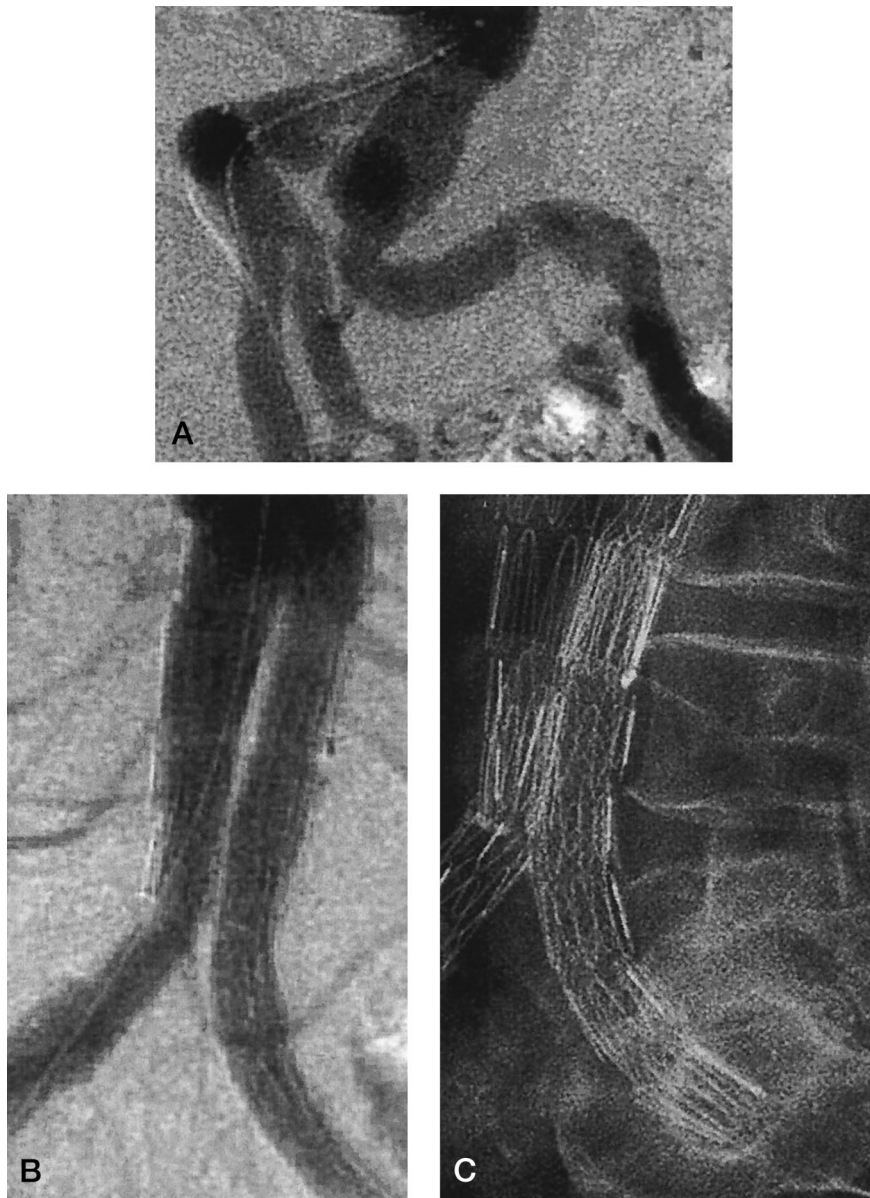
A, Preoperative angiogram showing tortuosity of both common iliac arteries, particularly the left. B, Intraoperative angiogram after Wallstent placement, showing the smoothly curved course and wide patency of the left limb. C, Postoperative abdominal radiograph showing the Wallstent in the left limb of the graft.
